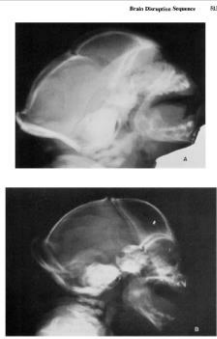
Lateral radiograph of skull. (A) Case 1. (B) Case 2. See notes introduction to chapter.
